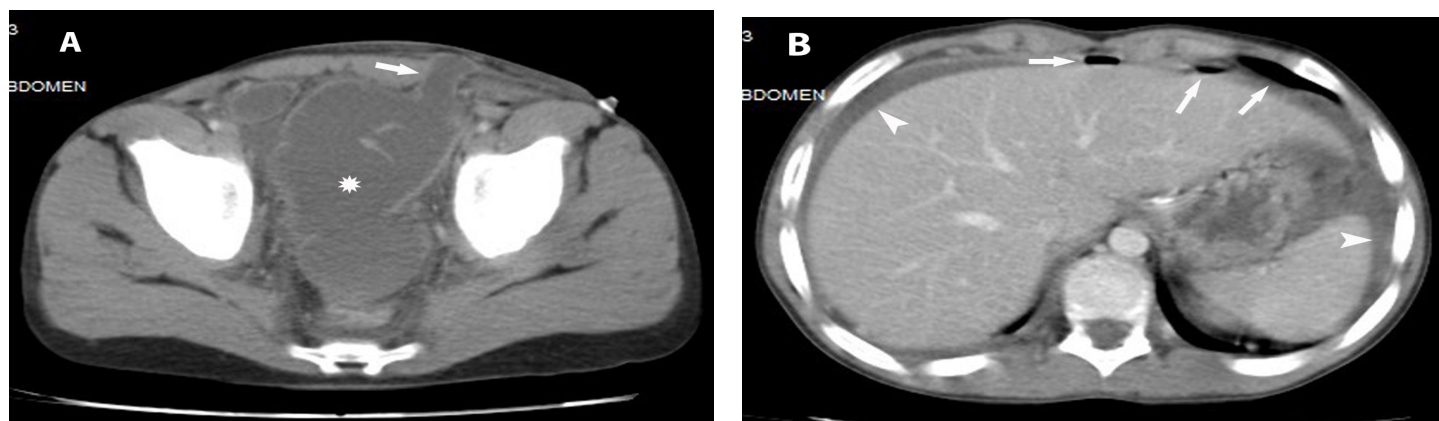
Axial computed tomography demonstrates the anterior abdominal wall defect and the herniated small bowel segment (arrow) with segmental ileus presented as dilatation of small bowel (*). B. Pneumoperitoneum (arrows) and free peritoneal fluid around the liver and spleen (arrowheads).
